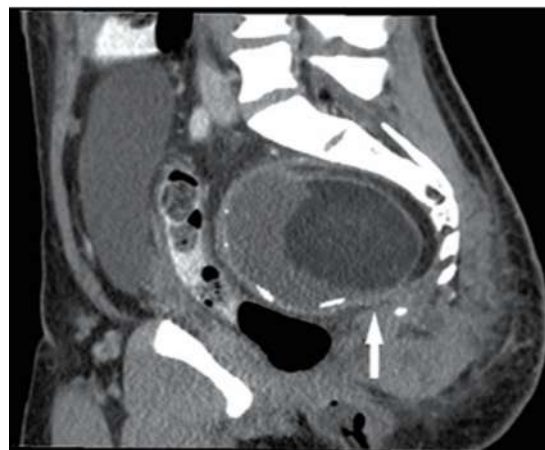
CT Shows pre-sacral mass.
